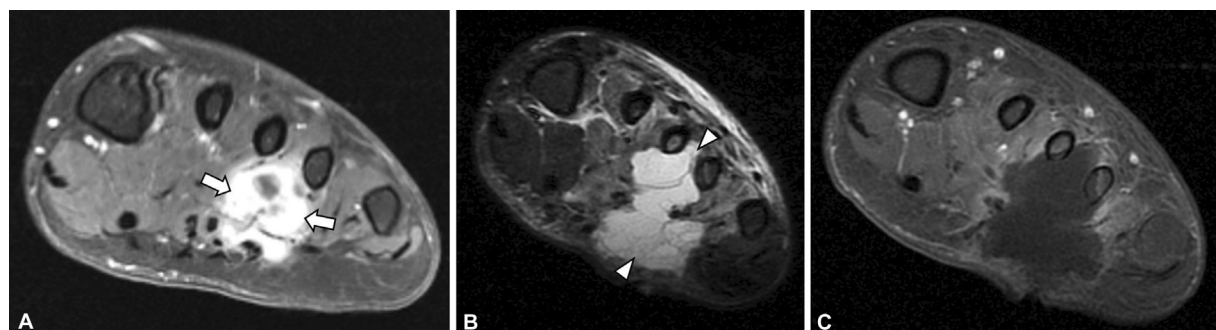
A 38-year-old woman with postoperative fluid collection after resection of a synovial sarcoma in the foot. (A) Axial T1-weighted fat-suppressed postcontrast magnetic resonance (MR) image shows an enhancing mass (arrows) in the forefoot consistent with a synovial sarcoma. Postoperative axial (B) T2-weighted fat-suppressed and (C) T1 fat-suppressed postcontrast MR images show a fluid collection (arrowheads) without internal enhancement consistent with a postoperative seroma.
